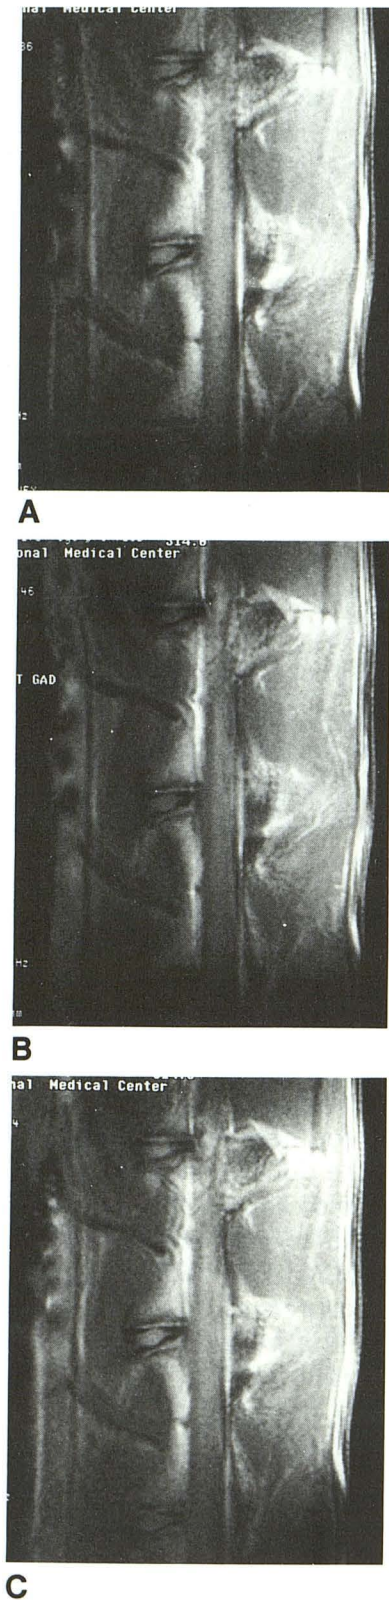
T1-weighted MR images after intravenous injection of 0.1 mmol/kg of gadopentetate dimeglumine. A, Before injection; B, 2 minutes after injection; and C, 60 minutes after injection. No enhancement of the disk is noted.
